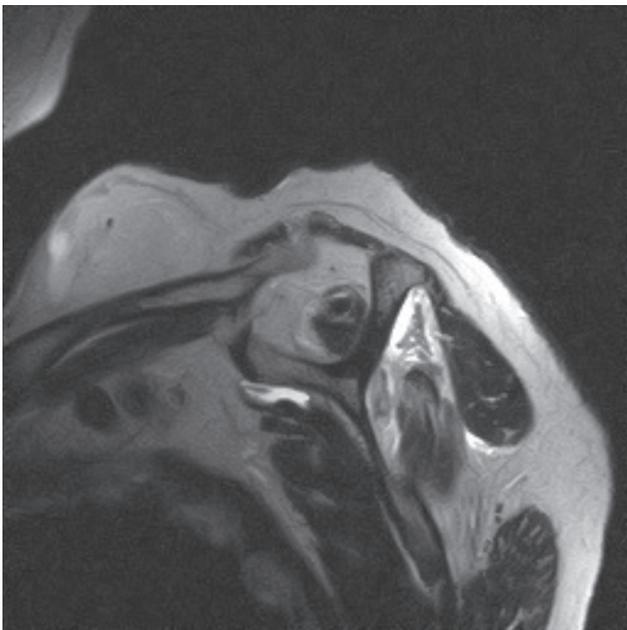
T1-weighted MRI showing grade 1 fatty infiltration in a patient with a large full-thickness supraspinatus tear.
